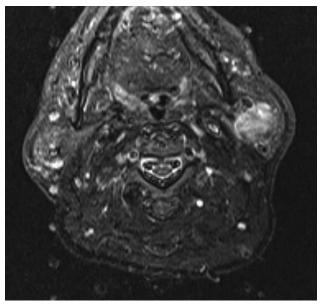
MRI axial plane image of the parotis mass after contrast injection.
